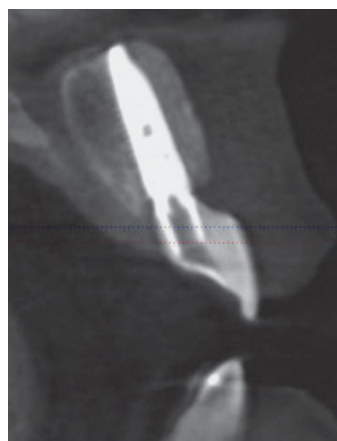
CBCT of the implant at the maxillary left central incisor 1 year after delivery. Note the radiopaque buccal image.
